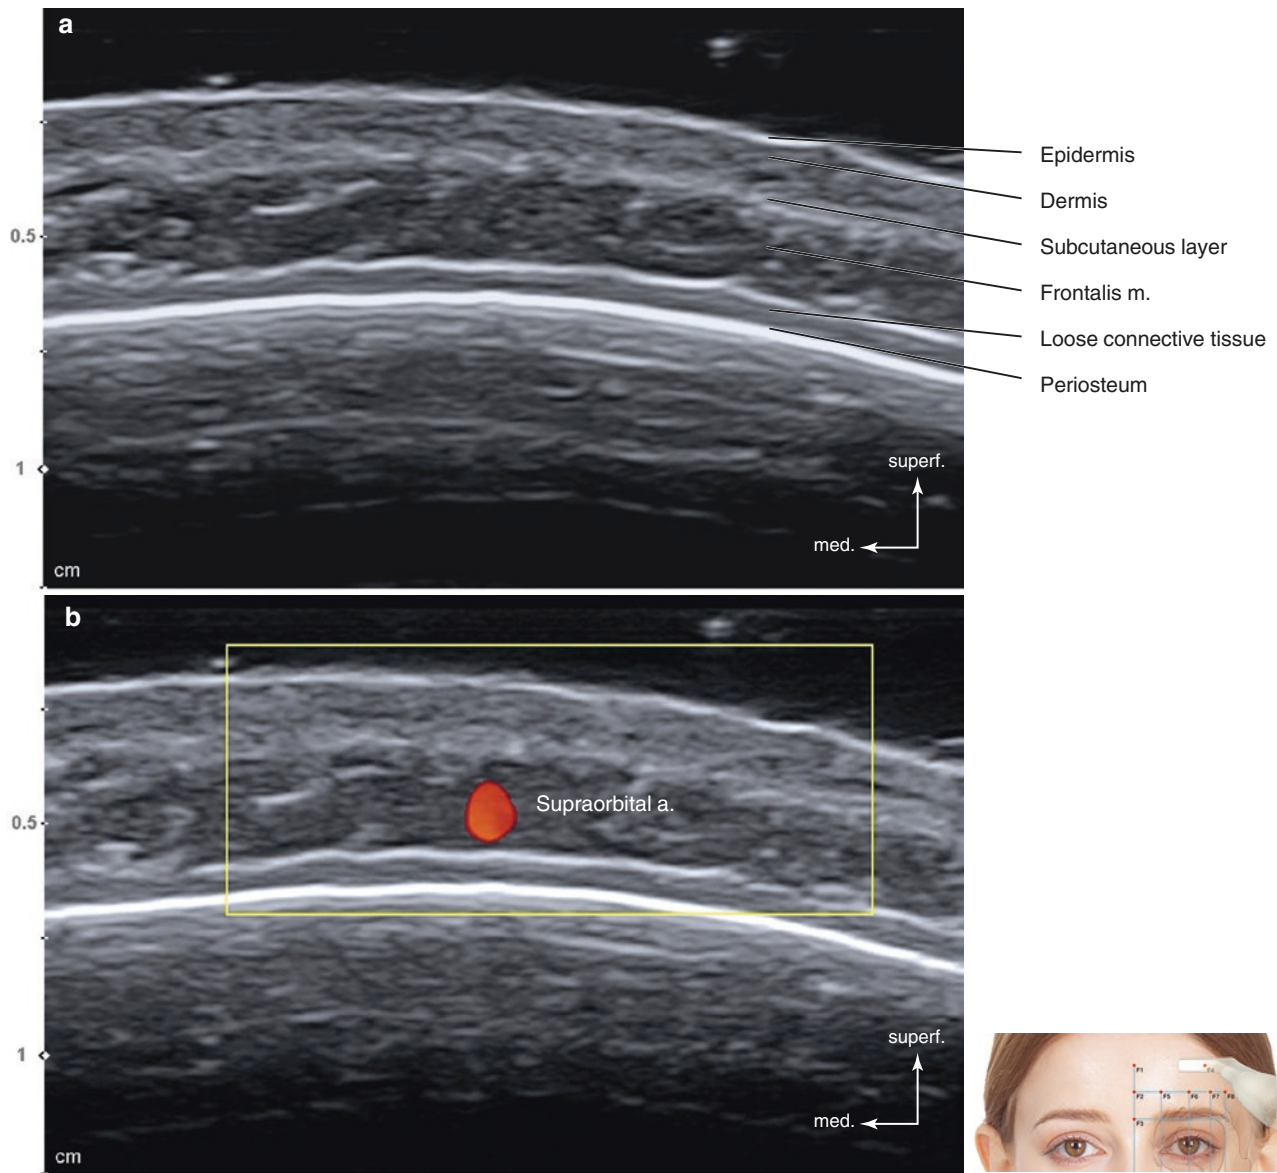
Ultrasonography on the frontal eminence (F4). (a) B mode (transverse view, 15 MHz by linear transducer) and (b) Doppler mode (transverse view, 15 MHz by linear transducer). (Published with kind permission of © Hee-Jin Kim 2020. All Rights Reserved)
